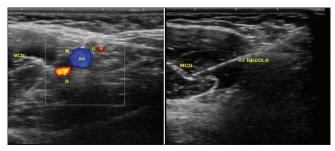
Colour Doppler with visualisation of axillary artery, vein and the location of nerves around the vessel. Also visualised is musculocutaneous nerve in the plane between biceps and coracobrachialis muscle. AA – Axillary artery;, AV – -Axillary vein;, M-Median nerve; U – -Ulnar nerve: R-Radial nerve: MCN – -Musculocutaneous nerve
